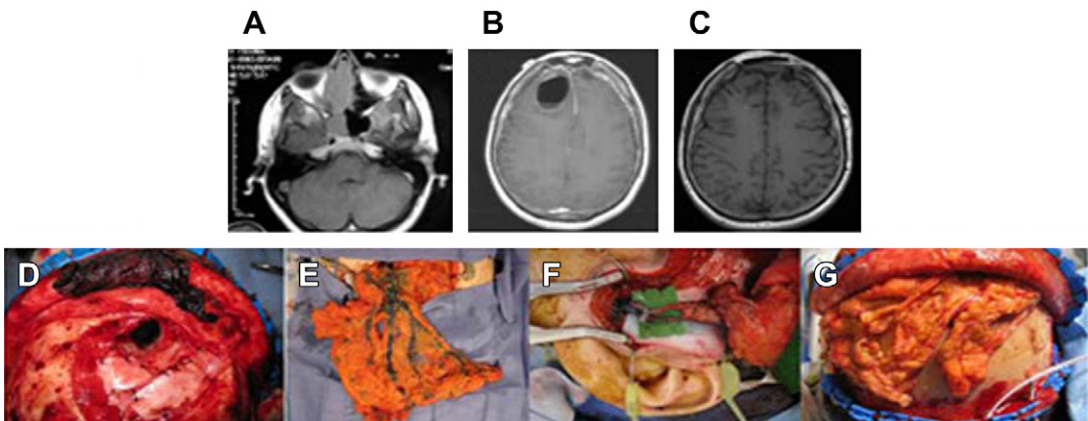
Delayed pneumocephalus from resorbed galeal pericranial graft. (A) MR image shows right nasoethmoidal esthesioneuroblastoma. (B) MR image shows delayed pneumocephalus. (C) Resolution of pneumocephalus with omental flap. (D–G) Intraoperative photographs of intracranial skull base repair base exposure. (D) Resorbed galeal pericranial graft. (E) Harvested omentum. (F) Anastomosis of superficial temporal vessels. (G) In-laid graft. (Adapted from Bilsky MH, Bentz B, Vitaz T, et al. Craniofacial resection for cranial base malignancies involving the infratemporal fossa. *Neurosurgery* 2005;57(4):339–47; with permission.)
